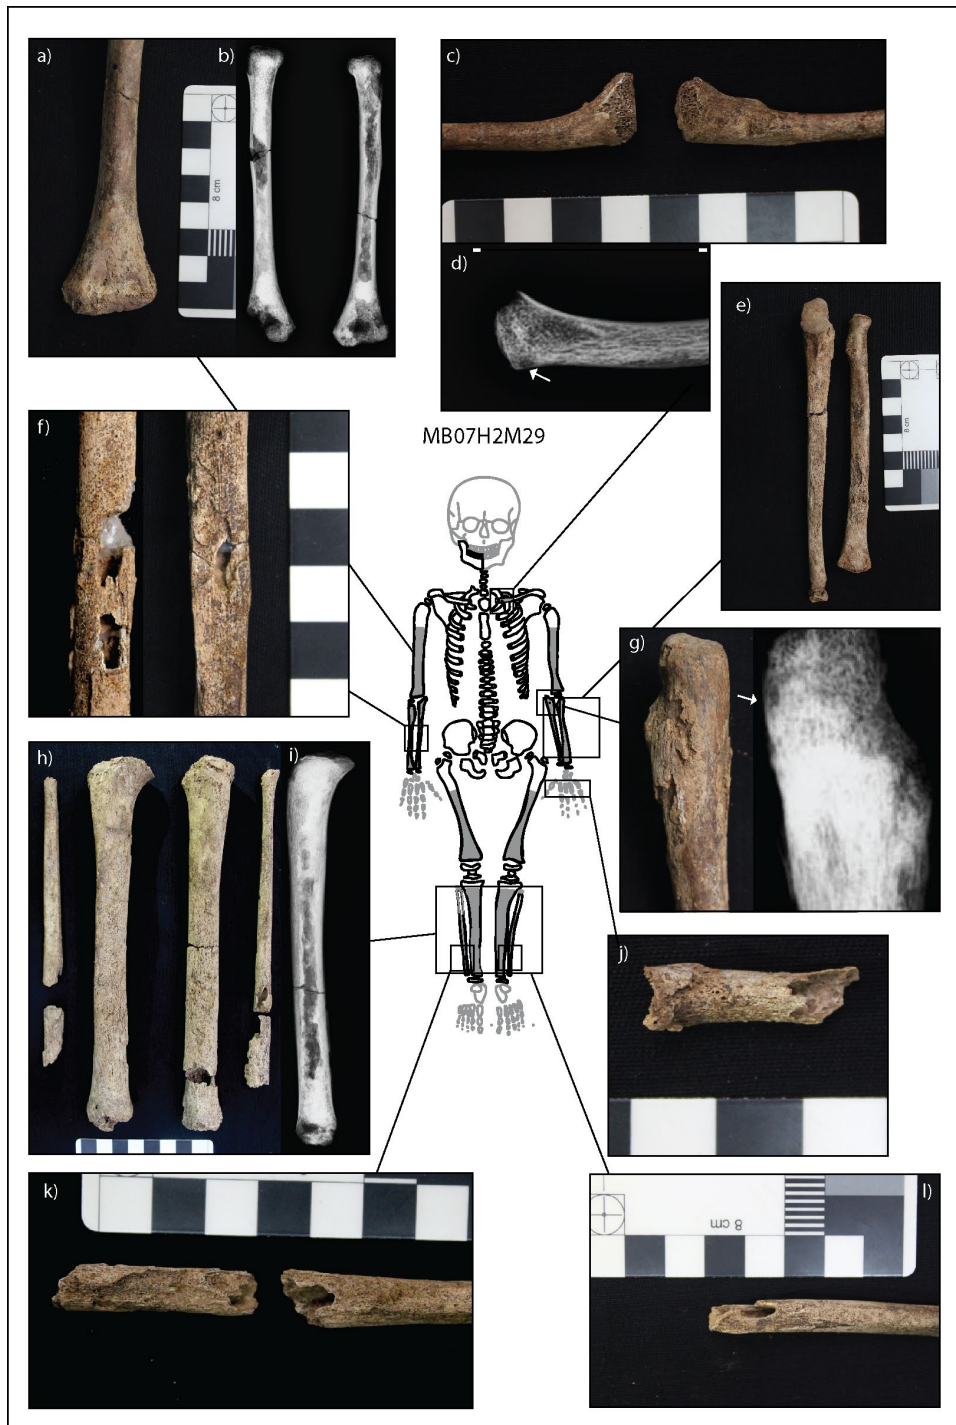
Expression of lesions related to infectious disease in MB07H2M29. Preserved bones are outlined in black, with absent bones outlined in light grey. An undetermined metacarpal is also present but not demonstrated in the figure as its skeletal position is unknown. The skeletal extent of OB lesions is indicated by dark grey fill. a) and b) SPNB on the distal ends of the humeri with cortical enlargement. c) Possible Higoumenakis sign of the left clavicle. d) Oval osteolytic lesion with a radiodense sclerotic margin on the inferior medial metaphysis of the left clavicle. e) Diffuse SPNB across the radii and ulnae. f) Two cavitations within nodes of SPNB on the midshafts of the right radius and ulna. g) Large node of SPNB on the proximal left ulna. Radiographs demonstrate a small oval osteolytic lesion with sclerotic margins within the node. h) Prolific SPNB across the tibiae and fibulae. i) Radiograph of the right tibia demonstrating sabre shin j) Dactylitis of a metacarpal. k) and l) Focal cavitations of the distal fibulae. The lesions are within nodes of new bone. Image: author's own from Vlok et al. (2020).
